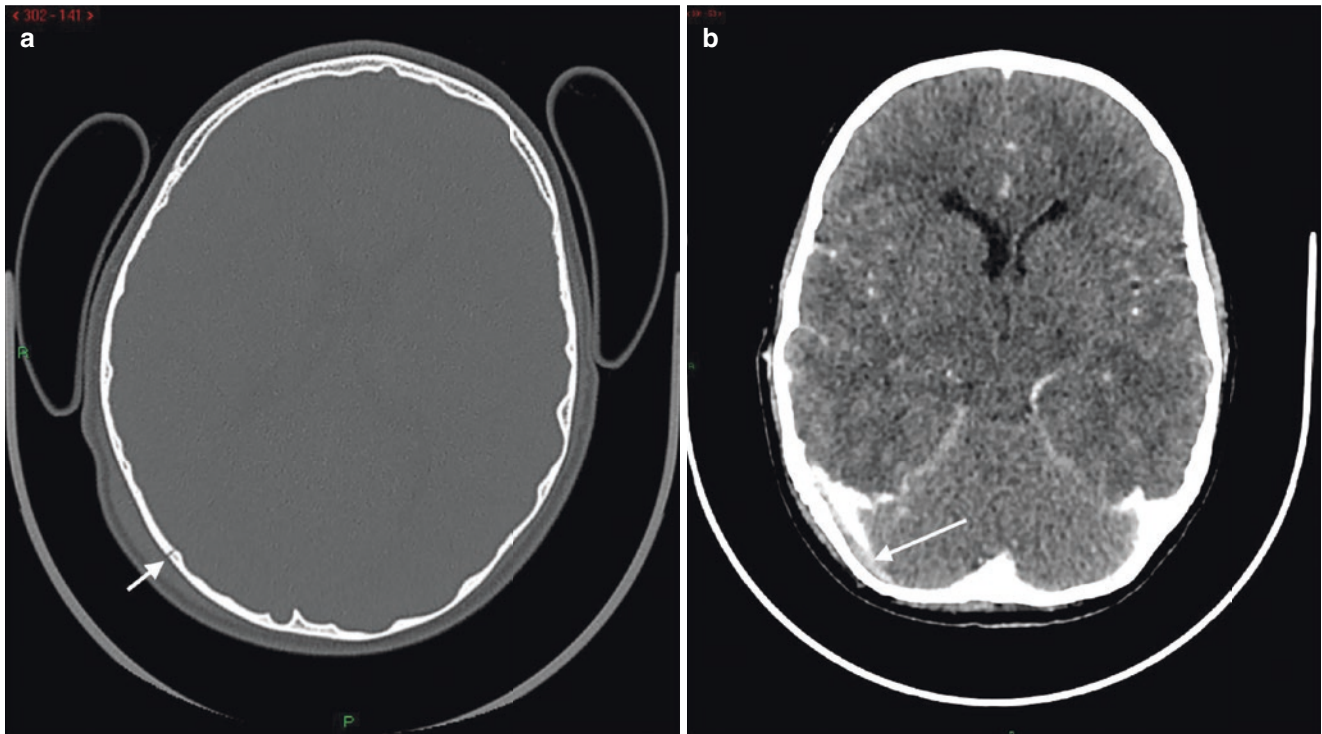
Right occipital skull fracture complicated by thrombus in the adjacent transverse sinus. Axial CT image (a) shows an undisplaced fracture in the right occipital bone. Subsequent axial contrast-enhanced
